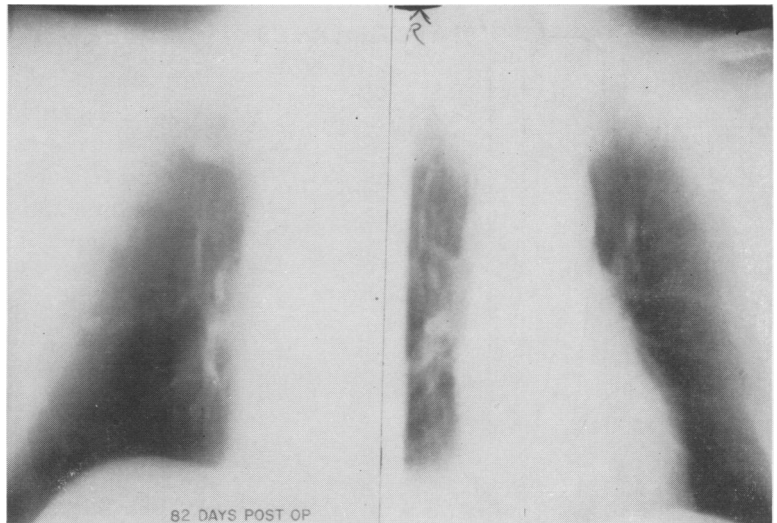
Chest x-rays of patient C. P. showing regression of islet cell pulmonary metastases after total gastrectomy. A chest x-ray had been negative one year prior to the preoperative film shown here.
